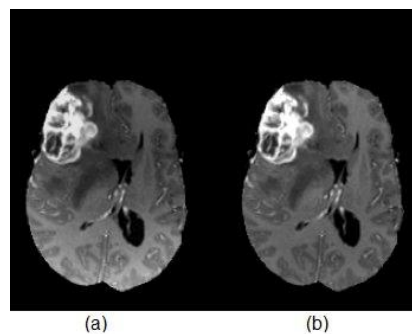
MRI scan (a) before (b) after N4ITK bias field correction.
